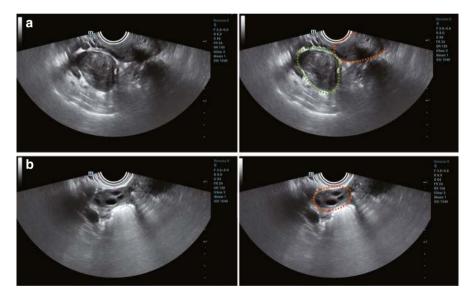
(a) Type 8 broad ligament fibroid: This ultrasound image shows that the fibroid is located on the right side of the uterus and is not visibly connected to the uterus. The uterus is outlined in orange; the broad ligament fibroid is circled in green. (b) Type 8 broad ligament fibroid: An image of the ovary ipsilateral to the fibroid. The right ovary is circled in orange
